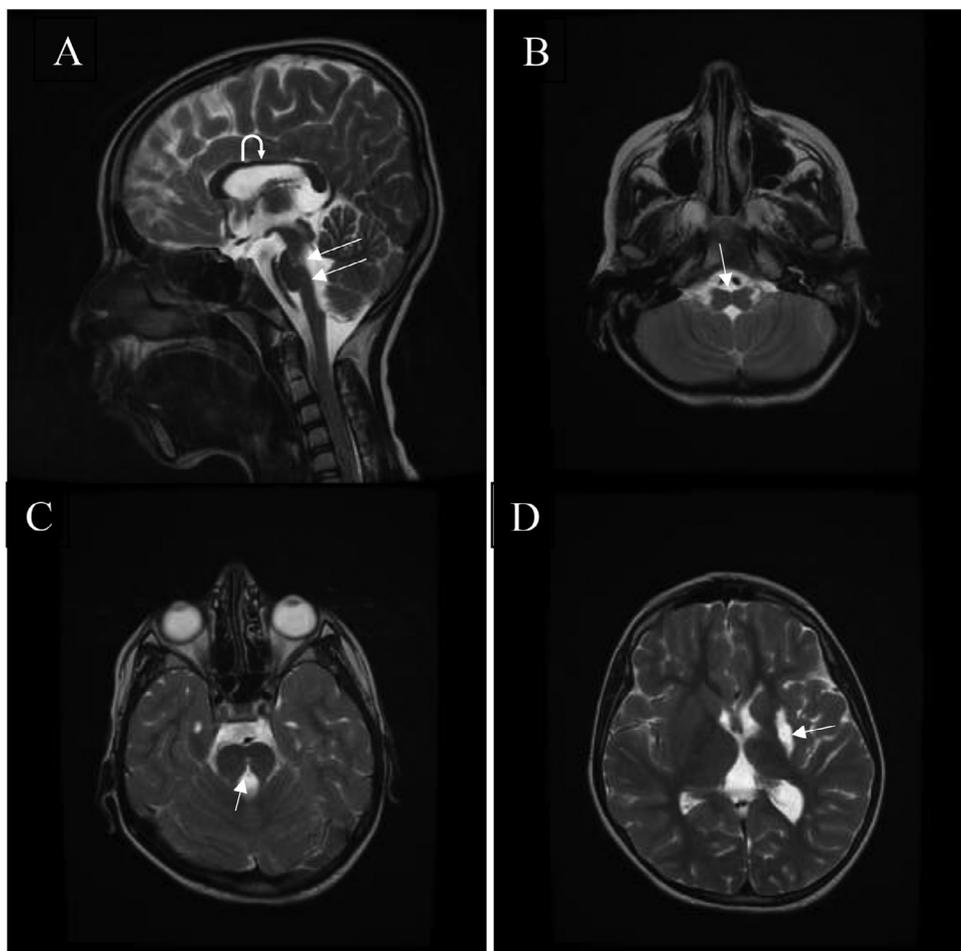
MRI midline sagittal T2-weighted Image of the brain (A) shows a small brainstem, in particular a small pons, with abnormal dorsal concavity (white straight arrows), thinning body of corpus callosum (curved white arrows). MRI Axial T2 weighted images through the pons and medulla (B and C) show the midline brainstem cleft (white straight arrow), butterfly-like appearance of the medulla. The floor of 4th ventricle is tent shaped with missing facial colliculi. MRI Axial T2 weight image (D) shows old insult in left basal ganglia (white straight arrow).
